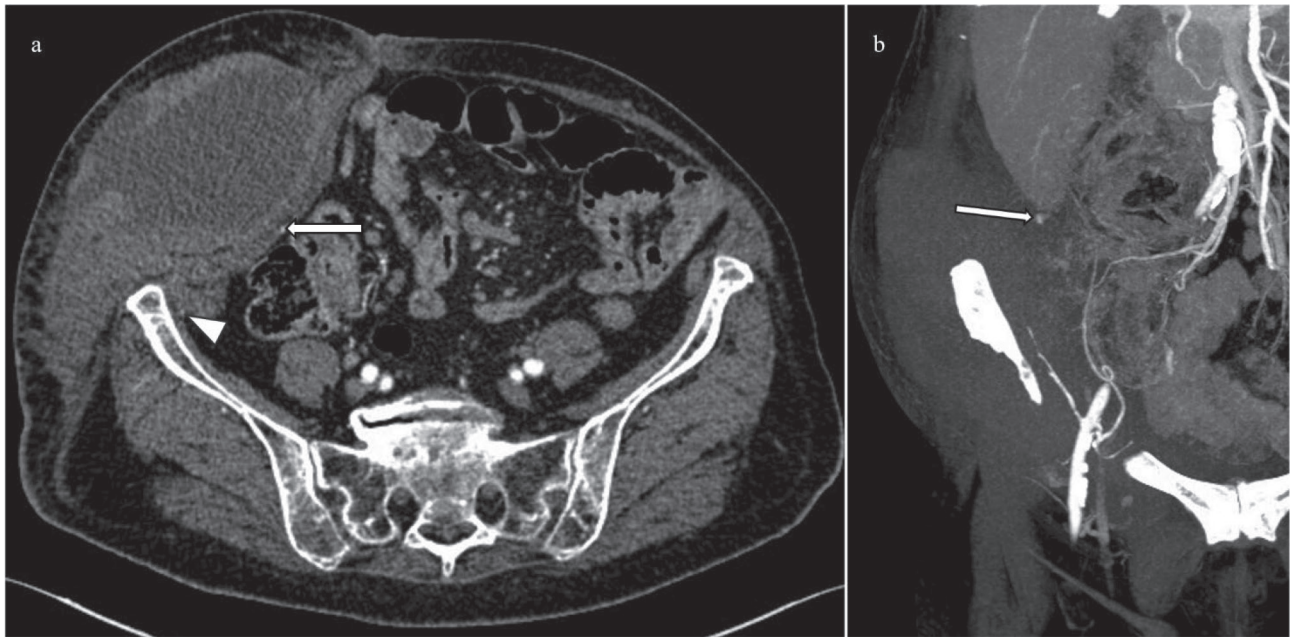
Right rectus sheath hematoma. (a) Pre-procedural axial arterial-phase CT image showing a large right rectus sheath hematoma refurnished by the inferior right epigastric artery (thin arrow) and the circumflex artery (arrowhead). (b) Pre-procedural coronal CT maximum intensity projection (MIP) reconstruction image showing the active bleeding (thin arrow) refurnished by the inferior right epigastric artery.
